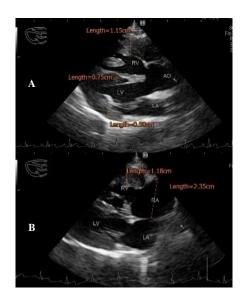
Right parasternal long axis 5-ch view, shows a right ventricular hypertrophy (two times the thickness of the left ventricular free wall), displacement of the aortic root on the right side, over the interventricular septum (overriding aorta).
